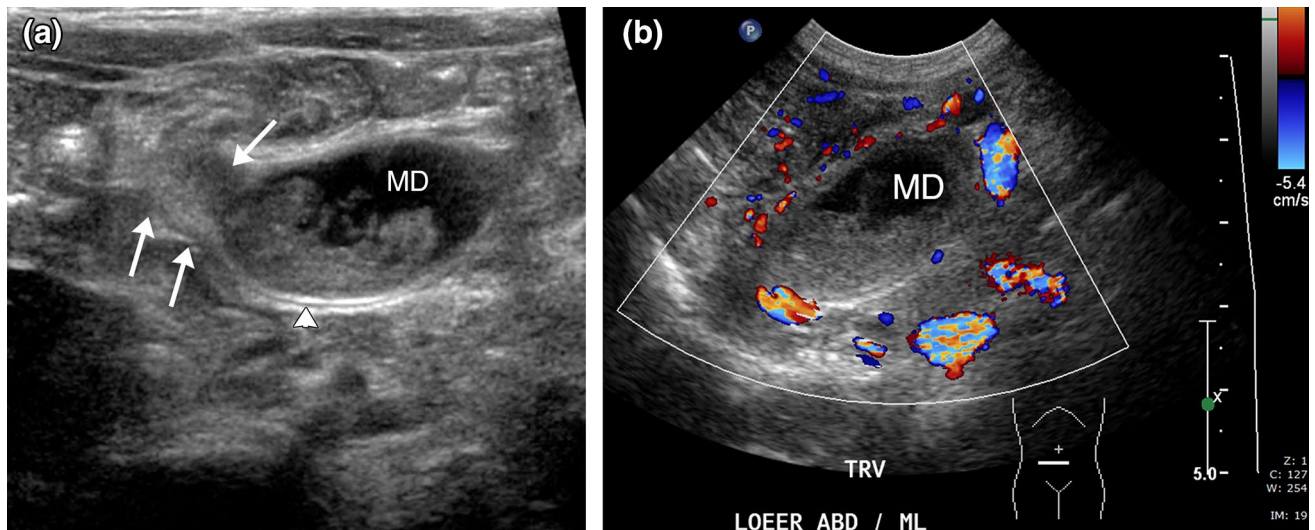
Infected hemorrhagic Meckel's diverticulum in a 12-month-old female with decreased oral intake, emesis, fever, and abdominal pain. a Gray scale and b Color Doppler images of the mid/lower abdomen obtained in transverse plane demonstrate a blind-ending loop of bowel (MD) that is connected to the remaining bowel (arrows
